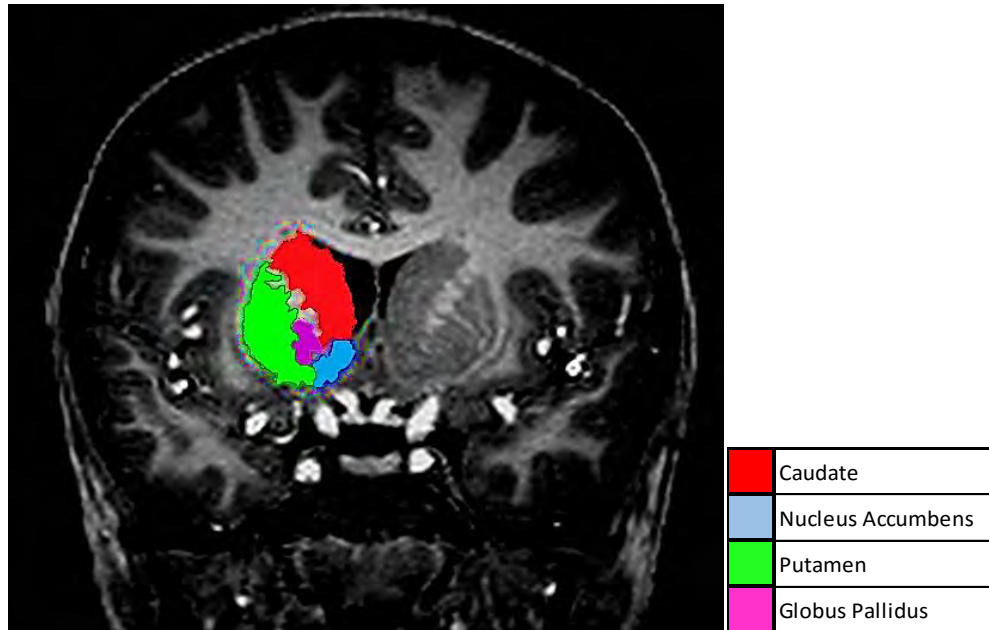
Coronal view of an MRI scan showing the four different structures that were traced in the right basal ganglia
